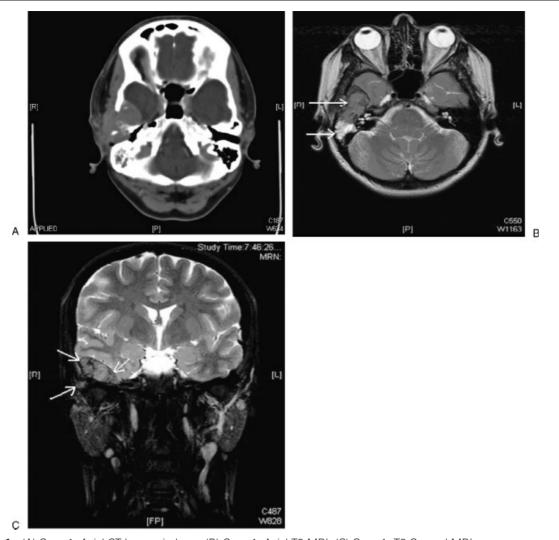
(A) Case 1: Axial CT bone windows. (B) Case 1: Axial T2 MRI. (C) Case 1: T2 Coronal MRI.
